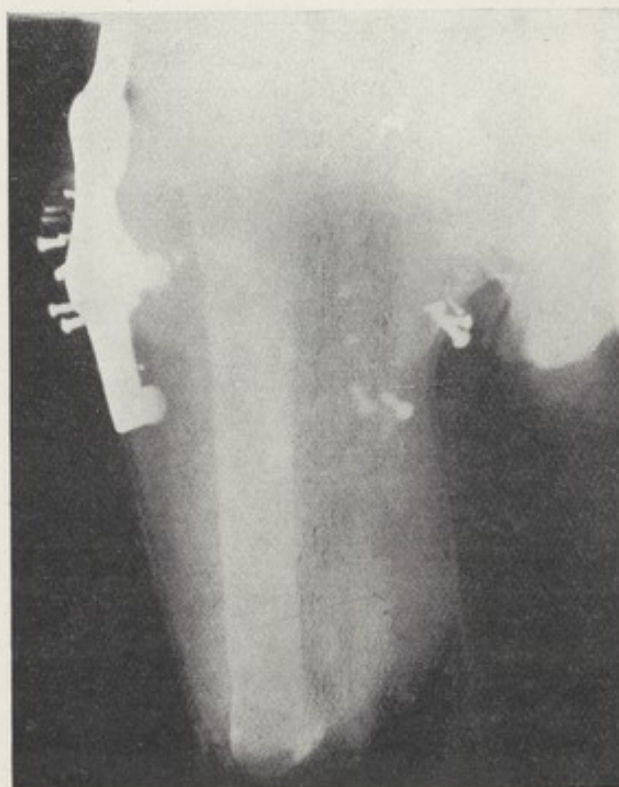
X-RAY PICTURE OF A LONG THIGH STUMP IN THE SOCKET OF A NO. 2 PROSTHESIS.
